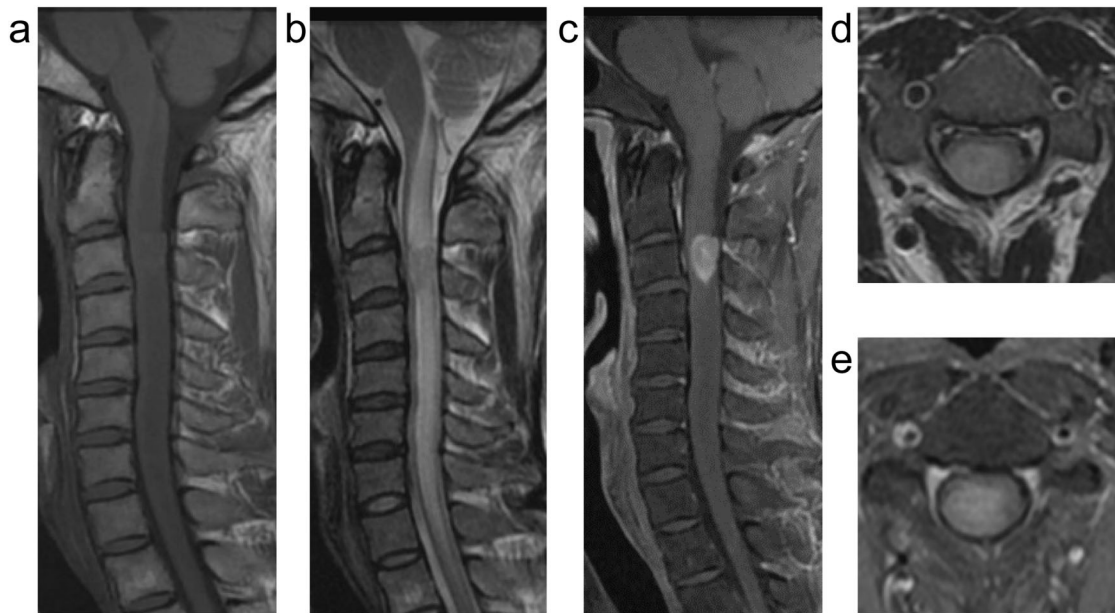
Preoperative cervical MR images. Sagittal images of T1-weighted (a), T2-weighted (b), and T1-weighted post-Gd (c) contrast administration and axial images of T2-weighted (d), and T1-weighted post-Gd (e) administration are presented. The tear-drop shaped
